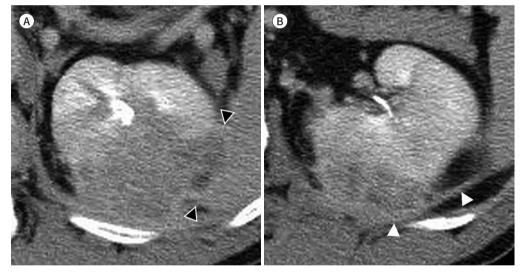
Renal inflammatory pseudotumor in a 69-year-old man who presented with left flank pain. A, B. Post-contrast CT demonstrates an inhomogeneously enhancing mass with infiltrative margins in the left kidney. The lesion obliterates the fat plane between the kidney and the spleen (black arrowheads) and involves the left renal fascia (white arrowheads).
